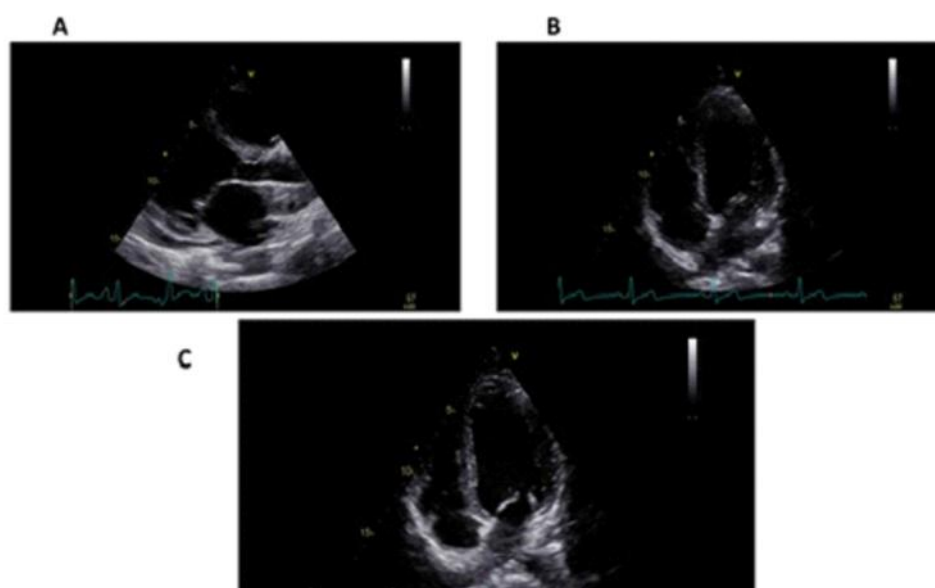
A. Parasternal long-axis view echocardiogram of the index case, B. Apical four-chamber view echocardiogram of the index case. C. Apical four-chamber view echocardiogram of the sibling
